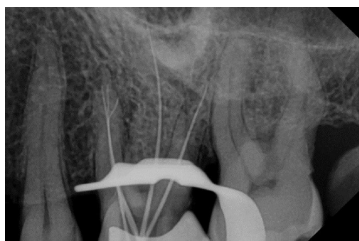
Radiograph for Determination of Working Length.
